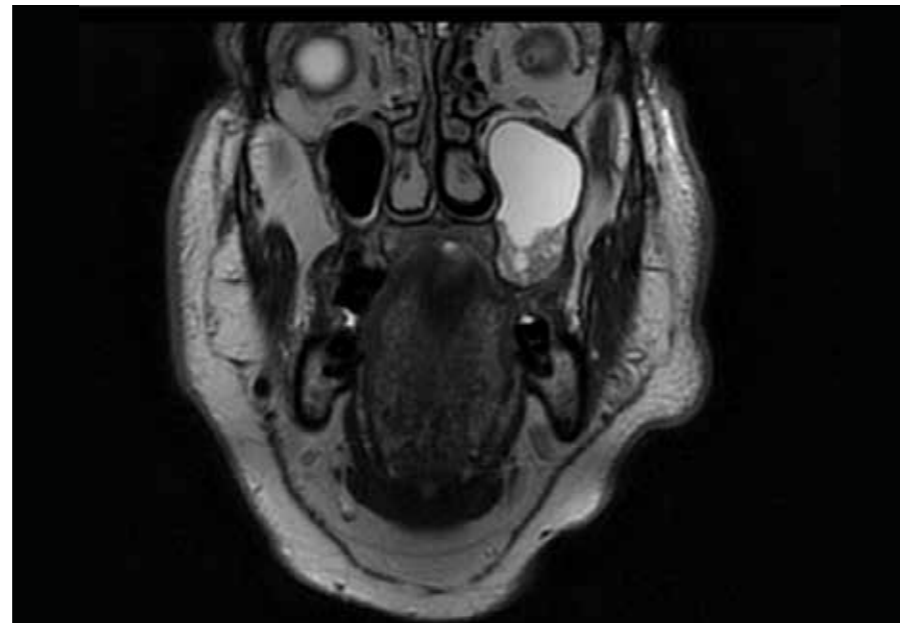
Coronal T2-weighted Magnetic resonance imaging taken on 07/12/2020 showing heterogeneous hypersignal area at the lower third of the maxillary sinus (cystic region) and homogeneous hypersignal area on the upper two thirds of the maxillary sinus (solid component)
